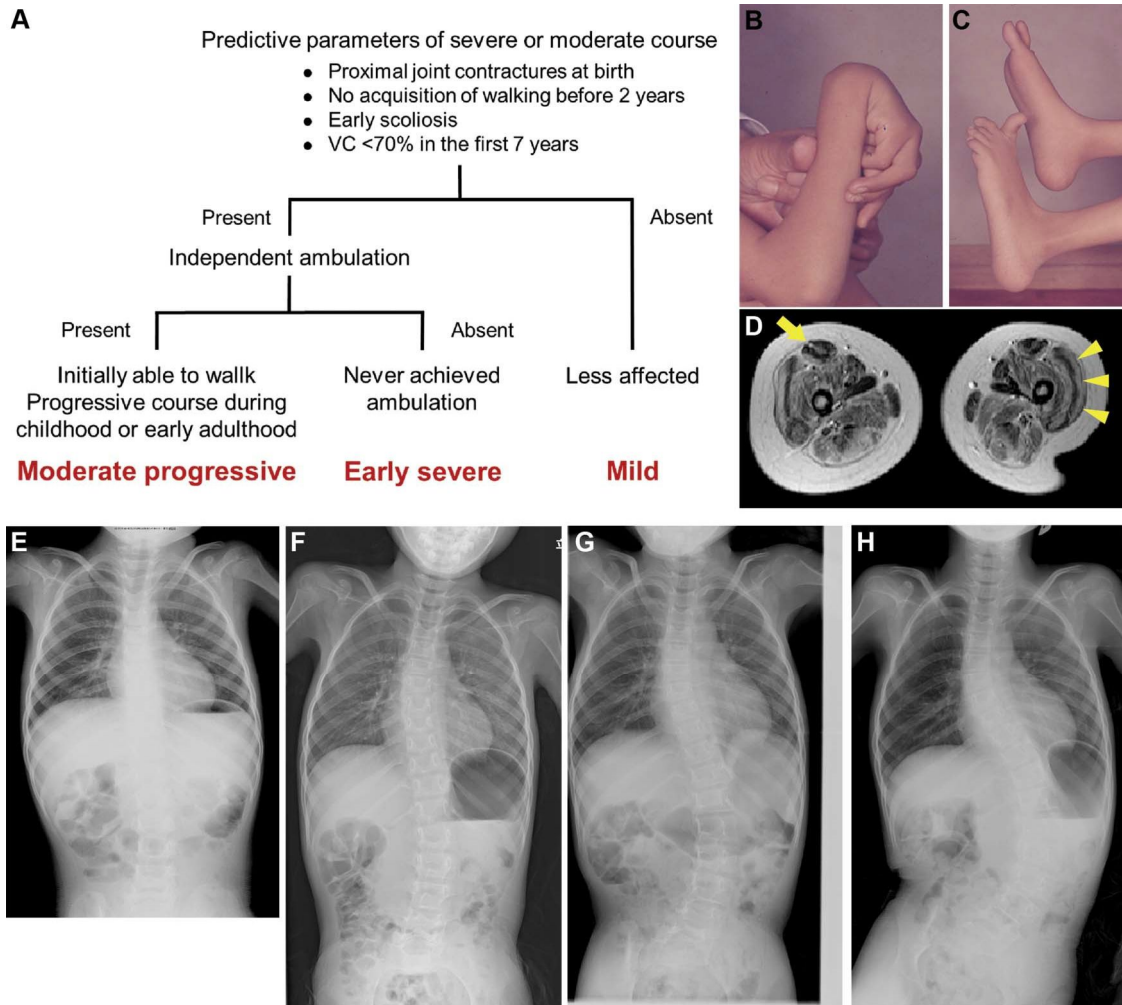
Phenotypic stratification of early-onset collagen VI-related myopathies; modification from Quijano-Roy et al¹⁰ and Briñas et al¹¹ (A). Typical distal hyperlaxity and protruding calcanei in a patient with Ullrich congenital muscular dystrophy (UCMD) (B,C). Diagnostic muscle MRI findings of the thigh (D): fatty regeneration along the fascia in the centre of the rectus femoris (arrow) and in the periphery of the vastus lateralis with relative sparing of its central part (arrowheads). Early-onset and rapidly progressive scoliosis in UCMD (E–H). E, 3.7; F, 6.1; G, 6.9; H, 7.9 years of age at assessment. (Images courtesy of Drs Ikuya Nonaka and Akihiko Ishiyama).
